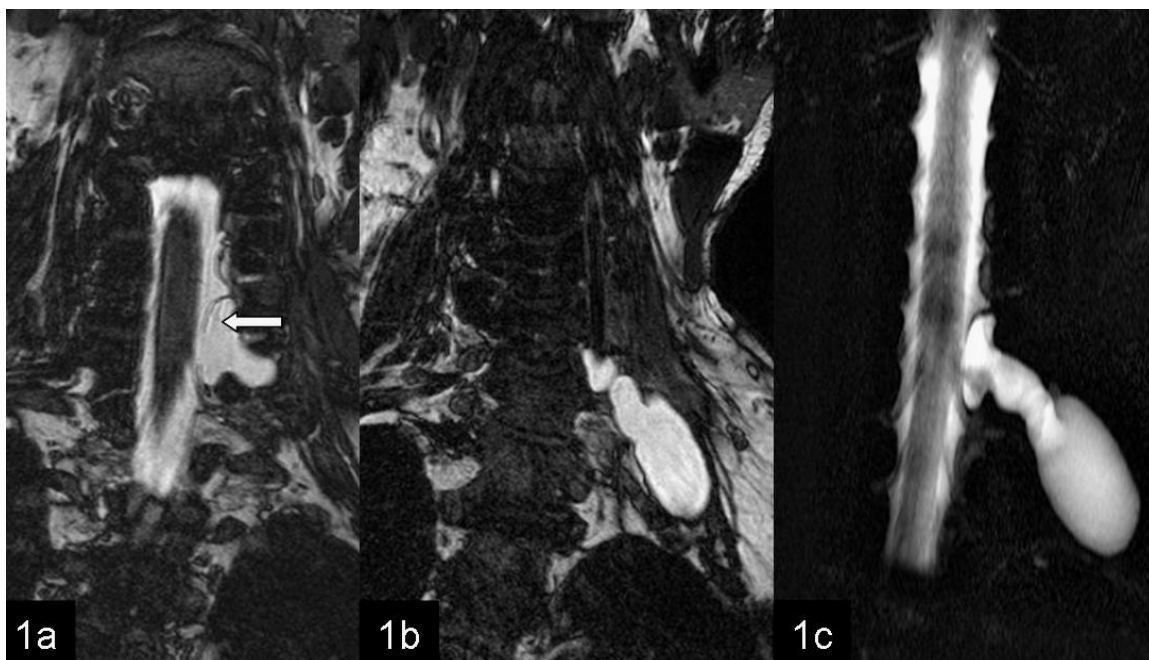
a-c: 1a-b Coronal T2-weighted fast spin-echo MRI. 1a- Dural tears (arrow) and intraspinal-foraminal part of Pseudomeningocele. 1b- Paravertebral part of pseudomeningocele. 1c-Magnetic resonance myelography images of pseudomeningocele.
